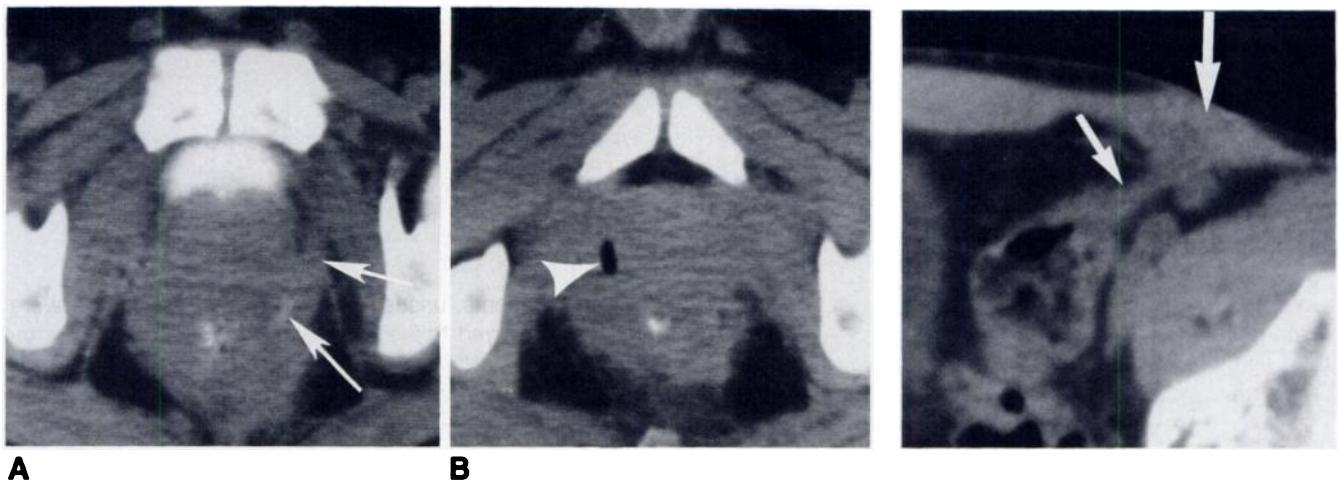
24-year-old man with history of Crohn's disease suspected to have abscess. CT shows evidence of marked inflammation of rectum with perirectal fistulae (arrows). Fistula extends into prostate bed (arrowhead).
